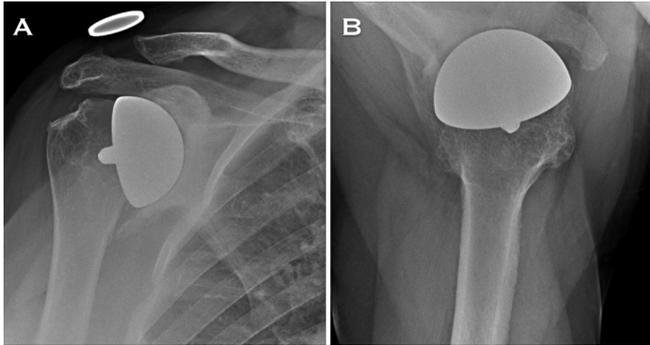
1A. X-ray in the anteroposterior view of a right shoulder showing a Copeland resurfacing shoulder arthroplasty with 11 years of follow-up. It can be noticed that there is an important glenoid erosion, without clinical transcendence. See figure 2. 1B. X-ray in the axillary view of a right shoulder showing a Copeland resurfacing shoulder arthroplasty with 11 years of follow-up.
